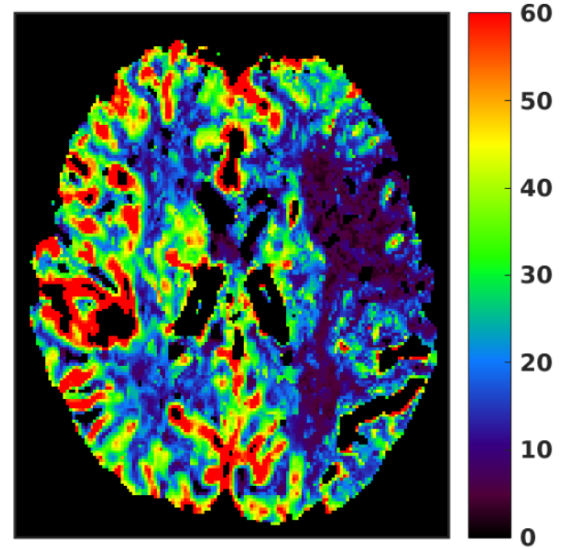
Effective cerebral blood flow  $BF^{eff}$  (ml/100g/min) calculated from deconvolution by means of Dispersion-Compliant Bases [5] (DCB) on stroke MRI data. The right hemisphere shows an infarcted region characterized by low values whereas the surrounding tissue is iso-perfused. We note that the infarcted region visually correlates with GDK results in Fig. 2.
